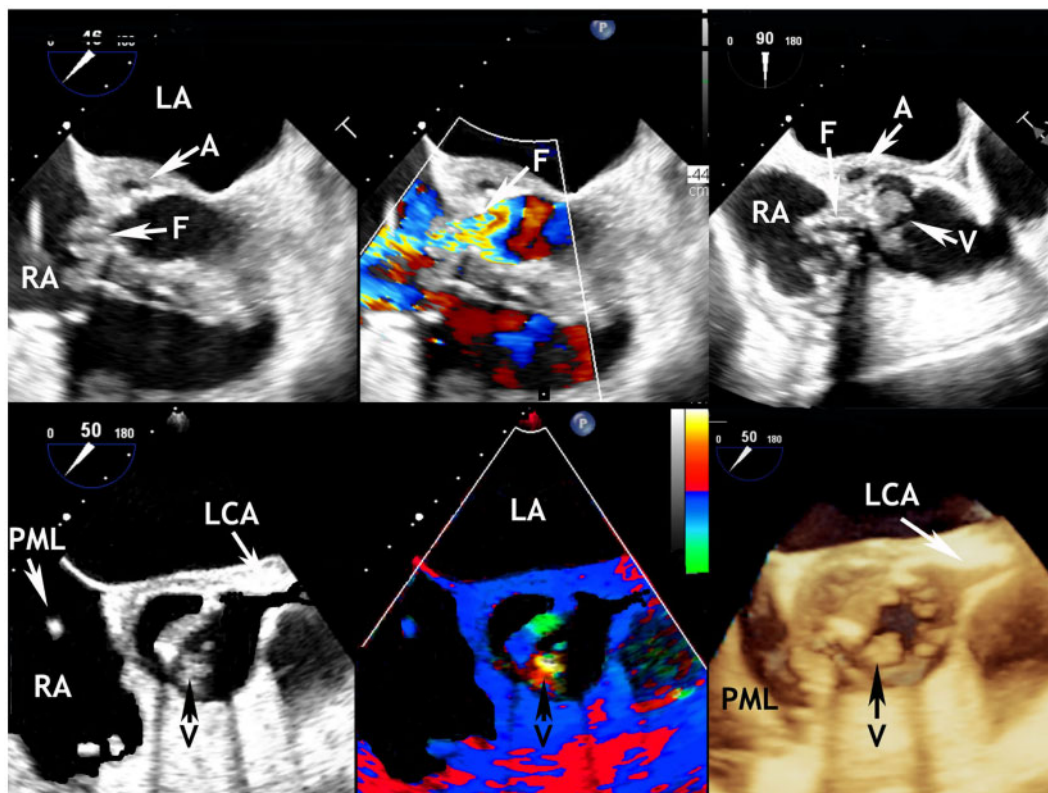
The upper panel shows paravalvular abscess, fistula to the right atrium complicating severe aortic valve endocarditis with vegetations are larger than 1 cm. Lower panel shows the aortic valve to be bicuspid with two- and three-dimensional display of a vegetation characterized by distinctive tissue Doppler motion pattern. A, abscess; F, fistula; LA, left atrium; LCA, left coronary artery; PML, pacemaker lead; RA, right atrium; V, vegetation.
